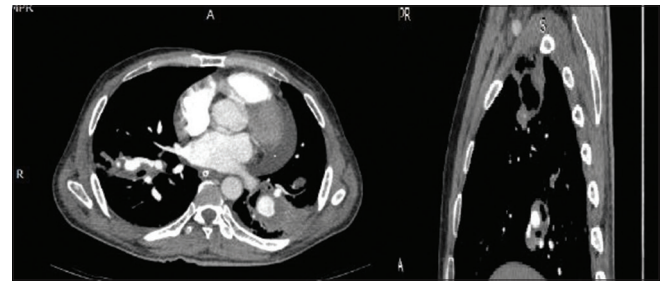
Computed tomography pulmonary angiogram revealed large cavitating consolidation in both lower lobes and right upper lobe with aneurysmal dilatation of the pulmonary artery and hypodense filling defect in segmental pulmonary arterial branches of the right upper lobe
